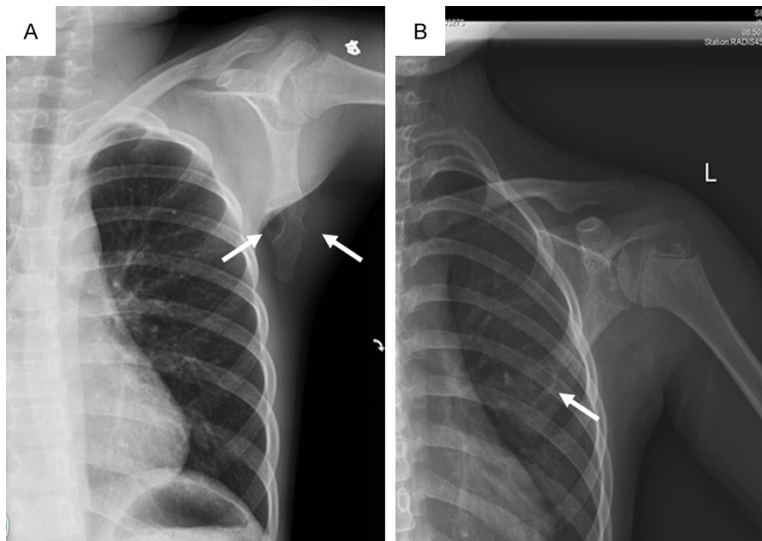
Plain anteroposterior X-rays of the left shoulder showing an irregularly shaped lesion located in the lower pole of the left scapular (A. The area indicated by the white arrow). Axial computed tomography scan reveals a round soft-tissue mass penetrating into both the anterior and posterior cortices of the left scapula (B. The area indicated by the white arrow).
